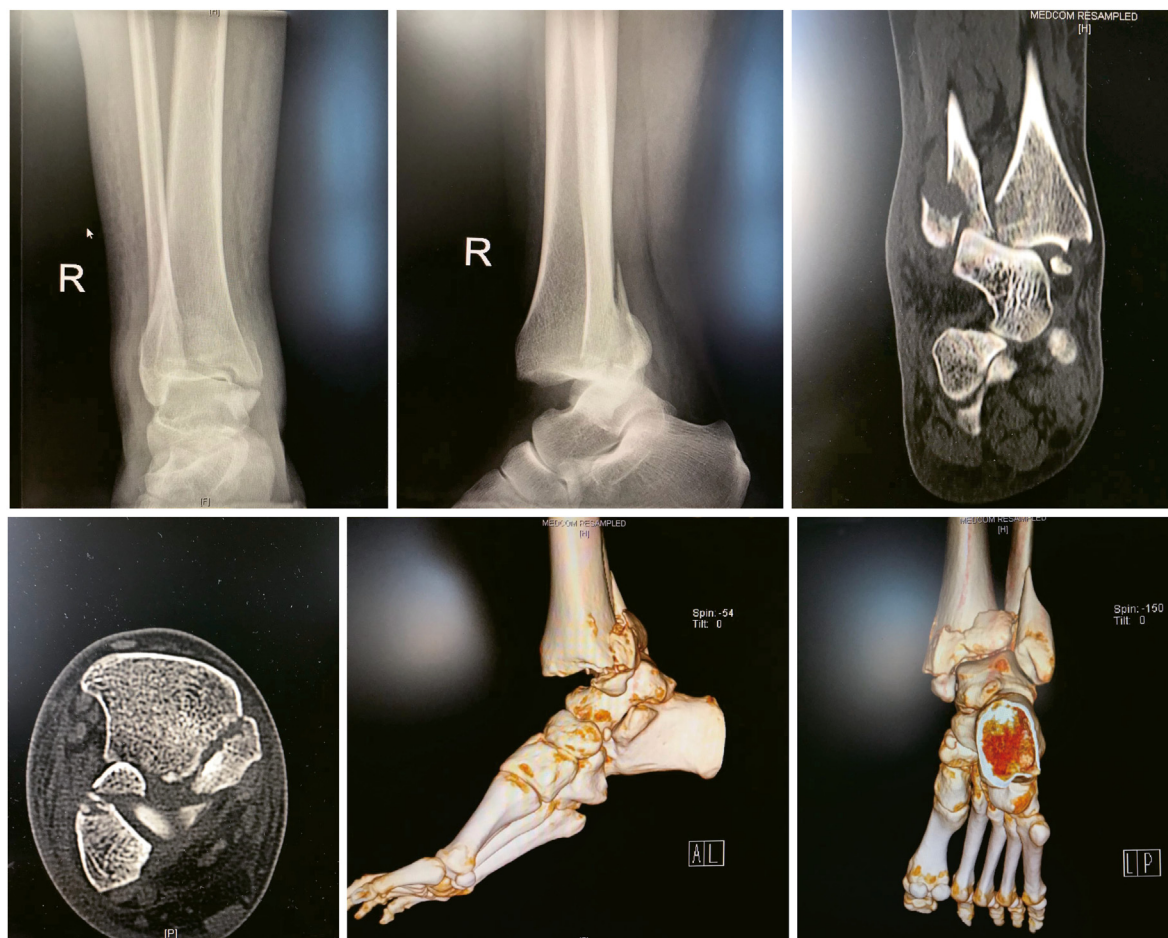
Preoperative imaging data (anteroposterior and lateral radiographs of the ankle joint, CT plain scan and 3D reconstruction).
